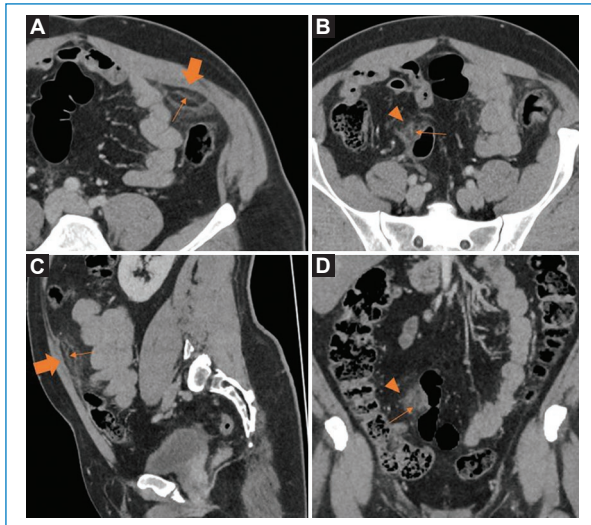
A 47-year-old male referred to the emergency department by his primary care physician for stabbing pain in the left hemiabdmen. On examination, firm abdomen with guarding on palpation in the left flank, with normal clinical analysis highlighting minimal leukocytosis and C-reactive protein at the upper limits of normal. Computed tomography is requested because of clinical symptoms suggestive of diverticulitis. Oblique axial reconstructions: upper at the level of descending colon (A) and lower, at the level of sigmoid (B). C: oblique sagittal reconstruction centered at the upper level. D: coronal reconstruction centered at the lower level, at the level of the sigmoid. Two ovoid lesions with inflammatory changes and fat hyperenhancement are visualized at the antimesenteric border of the descending colon (arrow) and sigmoid (arrowheads) with hyperattenuating halo and central dot sign (thin arrows) compatible with epiploic appendagitis in two locations.
